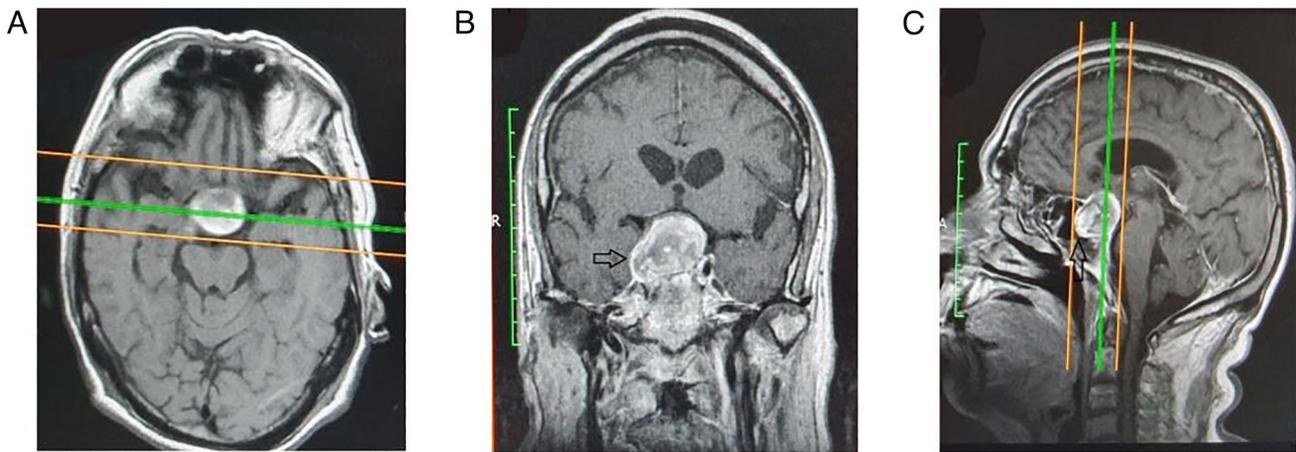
Pre-operative (MST approach) contrast enhanced T1 magnetic resonance image. (A) A large pituitary adenoma is depicted in the axial cut. (B) Coronal cut in the same patient. Note the lateral extension to the Rt cavernous sinus (arrow). (C) In the sagittal cut, the erosion/expansion in the sphenoid sinus (arrow) can be seen.
